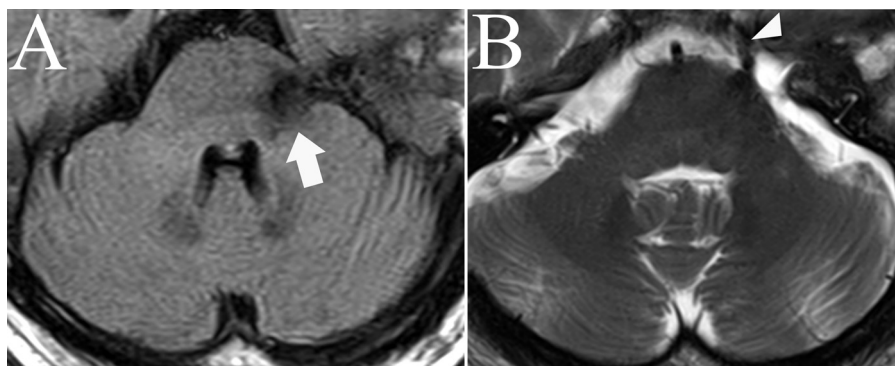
Axial postoperative FLAIR-weighted (A) and T2-weighted MRI (B) scan verifying complete resection of the cavernous malformation (white arrow) and continuity of the trigeminal nerve (arrowheads).
